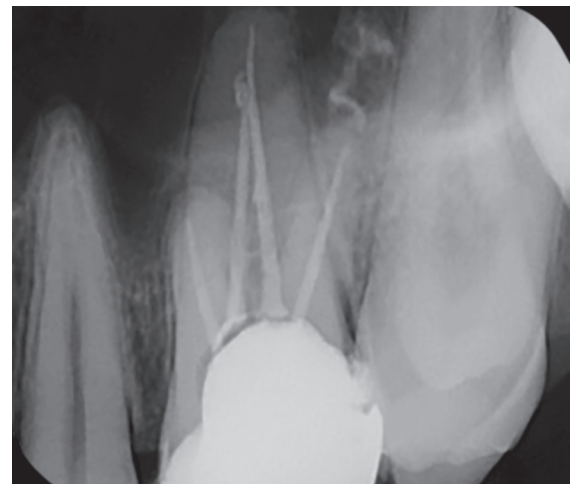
Immediate postobturation radiograph with 26
